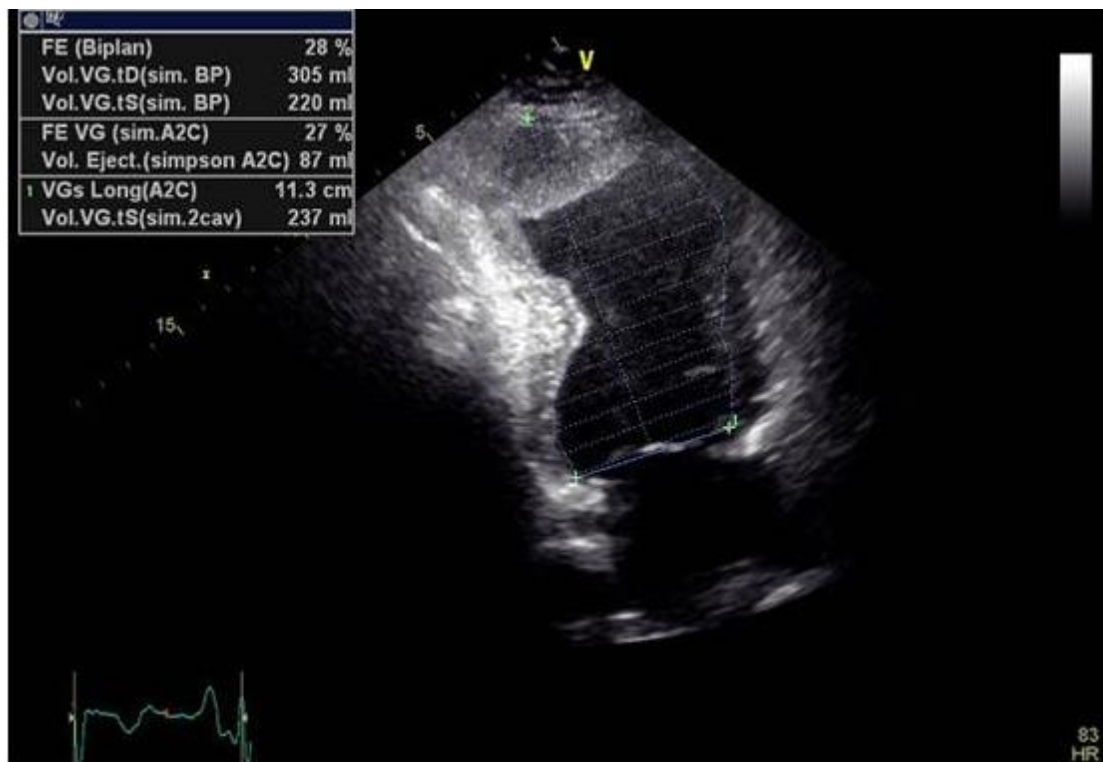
The incidence apical 2 Chambers showed a huge aneurysm of the left ventricle with apical thrombus.
